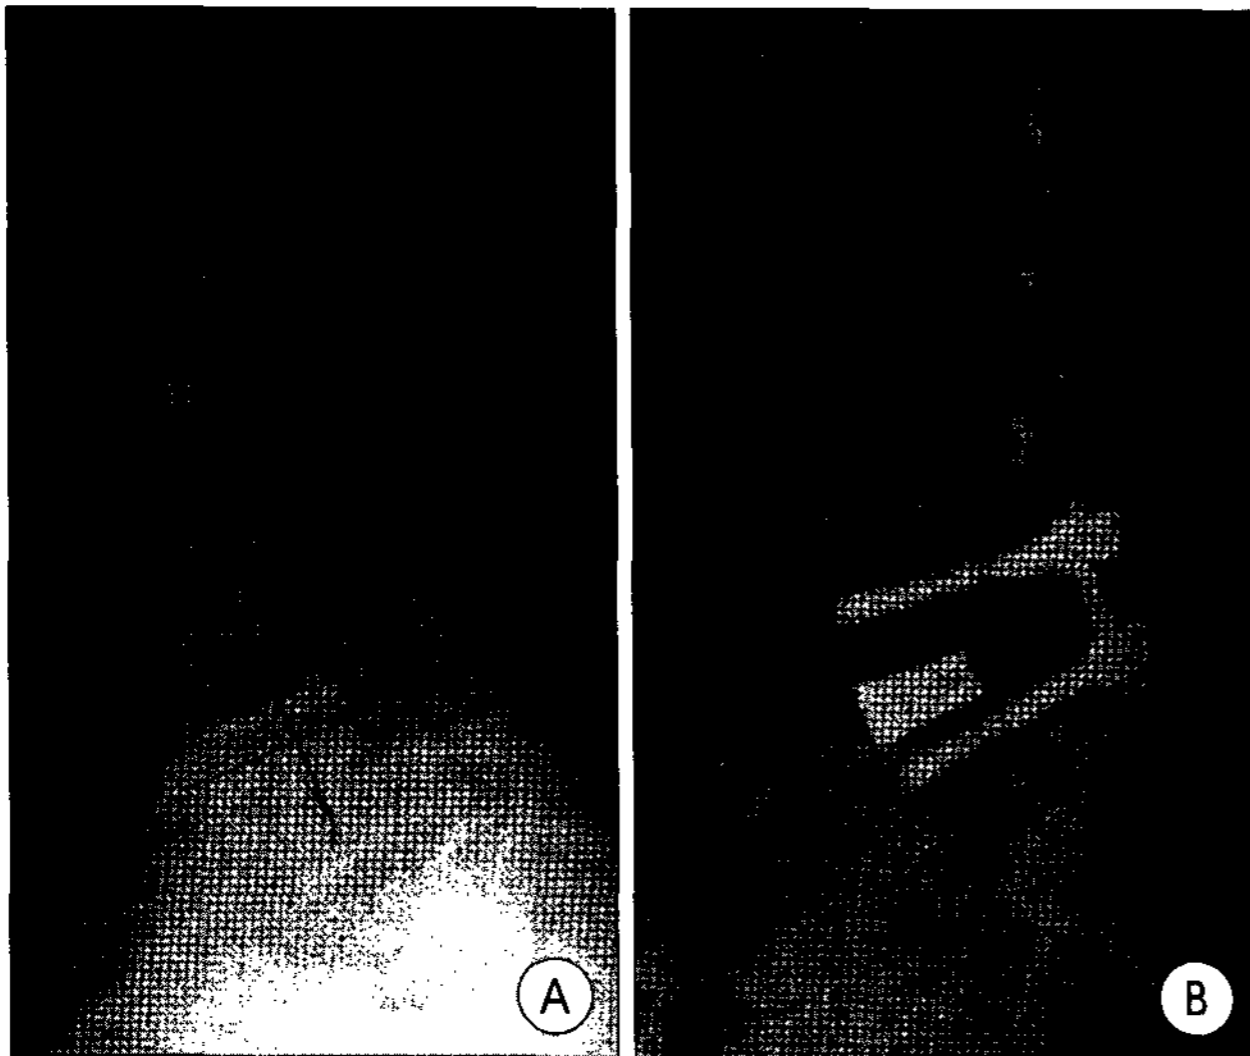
Example of segmental lordotic curve restoration. A : preoperative lateral simple radiograph shows degenerative spondylolisthesis on L4-5 level with decreased disc height. B : postoperative film shows circumferential fusion using lordotic curve cage with restoration of lordotic curve and increased disc height.
